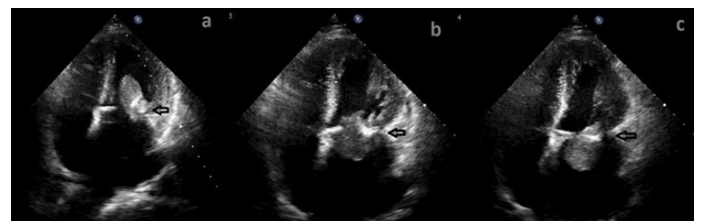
a. Transthoracic image of mobile giant myxoma in left ventricle, b. Myxoma moves through the mitral valve, c. Myxoma moves through left atrium
